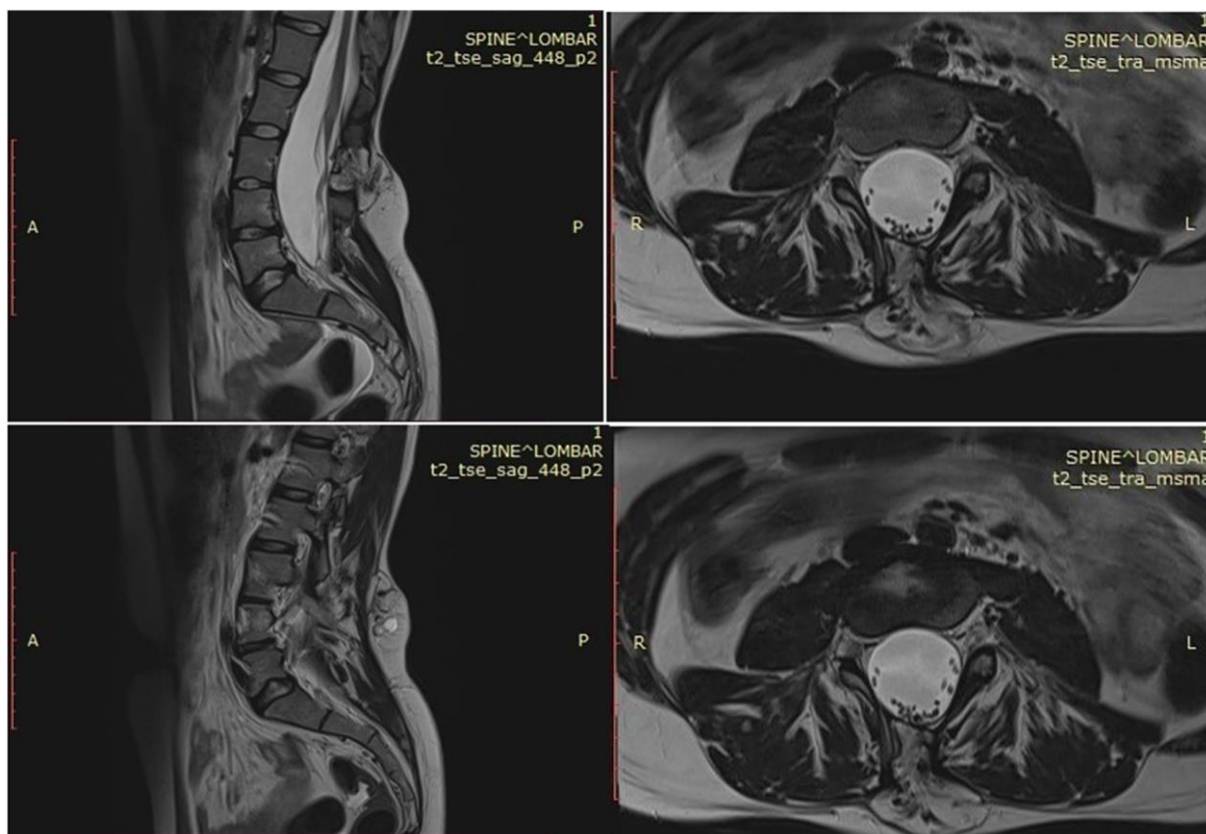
Figure 1 shows a 1.5 Tesla MRI with IV contrast of the lumbo-sacral region, revealing spinal dysraphism, spina bifida occulta at the level of the L3 vertebra, a tethered cord, and an extradural lipoma communicating with subcutaneous fatty swelling.
